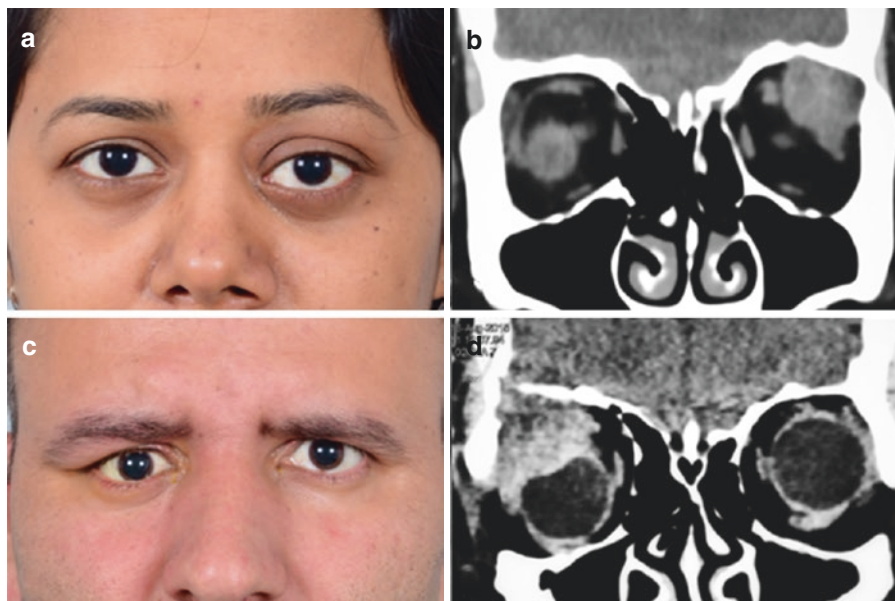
Lacrimal gland tumors. (a) An 18-year-old female with left proptosis. (b) Coronal CT orbit reveals a left supertemporal homogenous orbital mass in the lacrimal fossa, with bony indentation and no bone destruction. (c) A 38-year-old male with right proptosis complaining of severe diplopia in right lateral gaze. (d) Coronal CT orbit shows a nonhomogenous ill-defined mass lesion in the right lacrimal fossa with evidence of bone destruction
